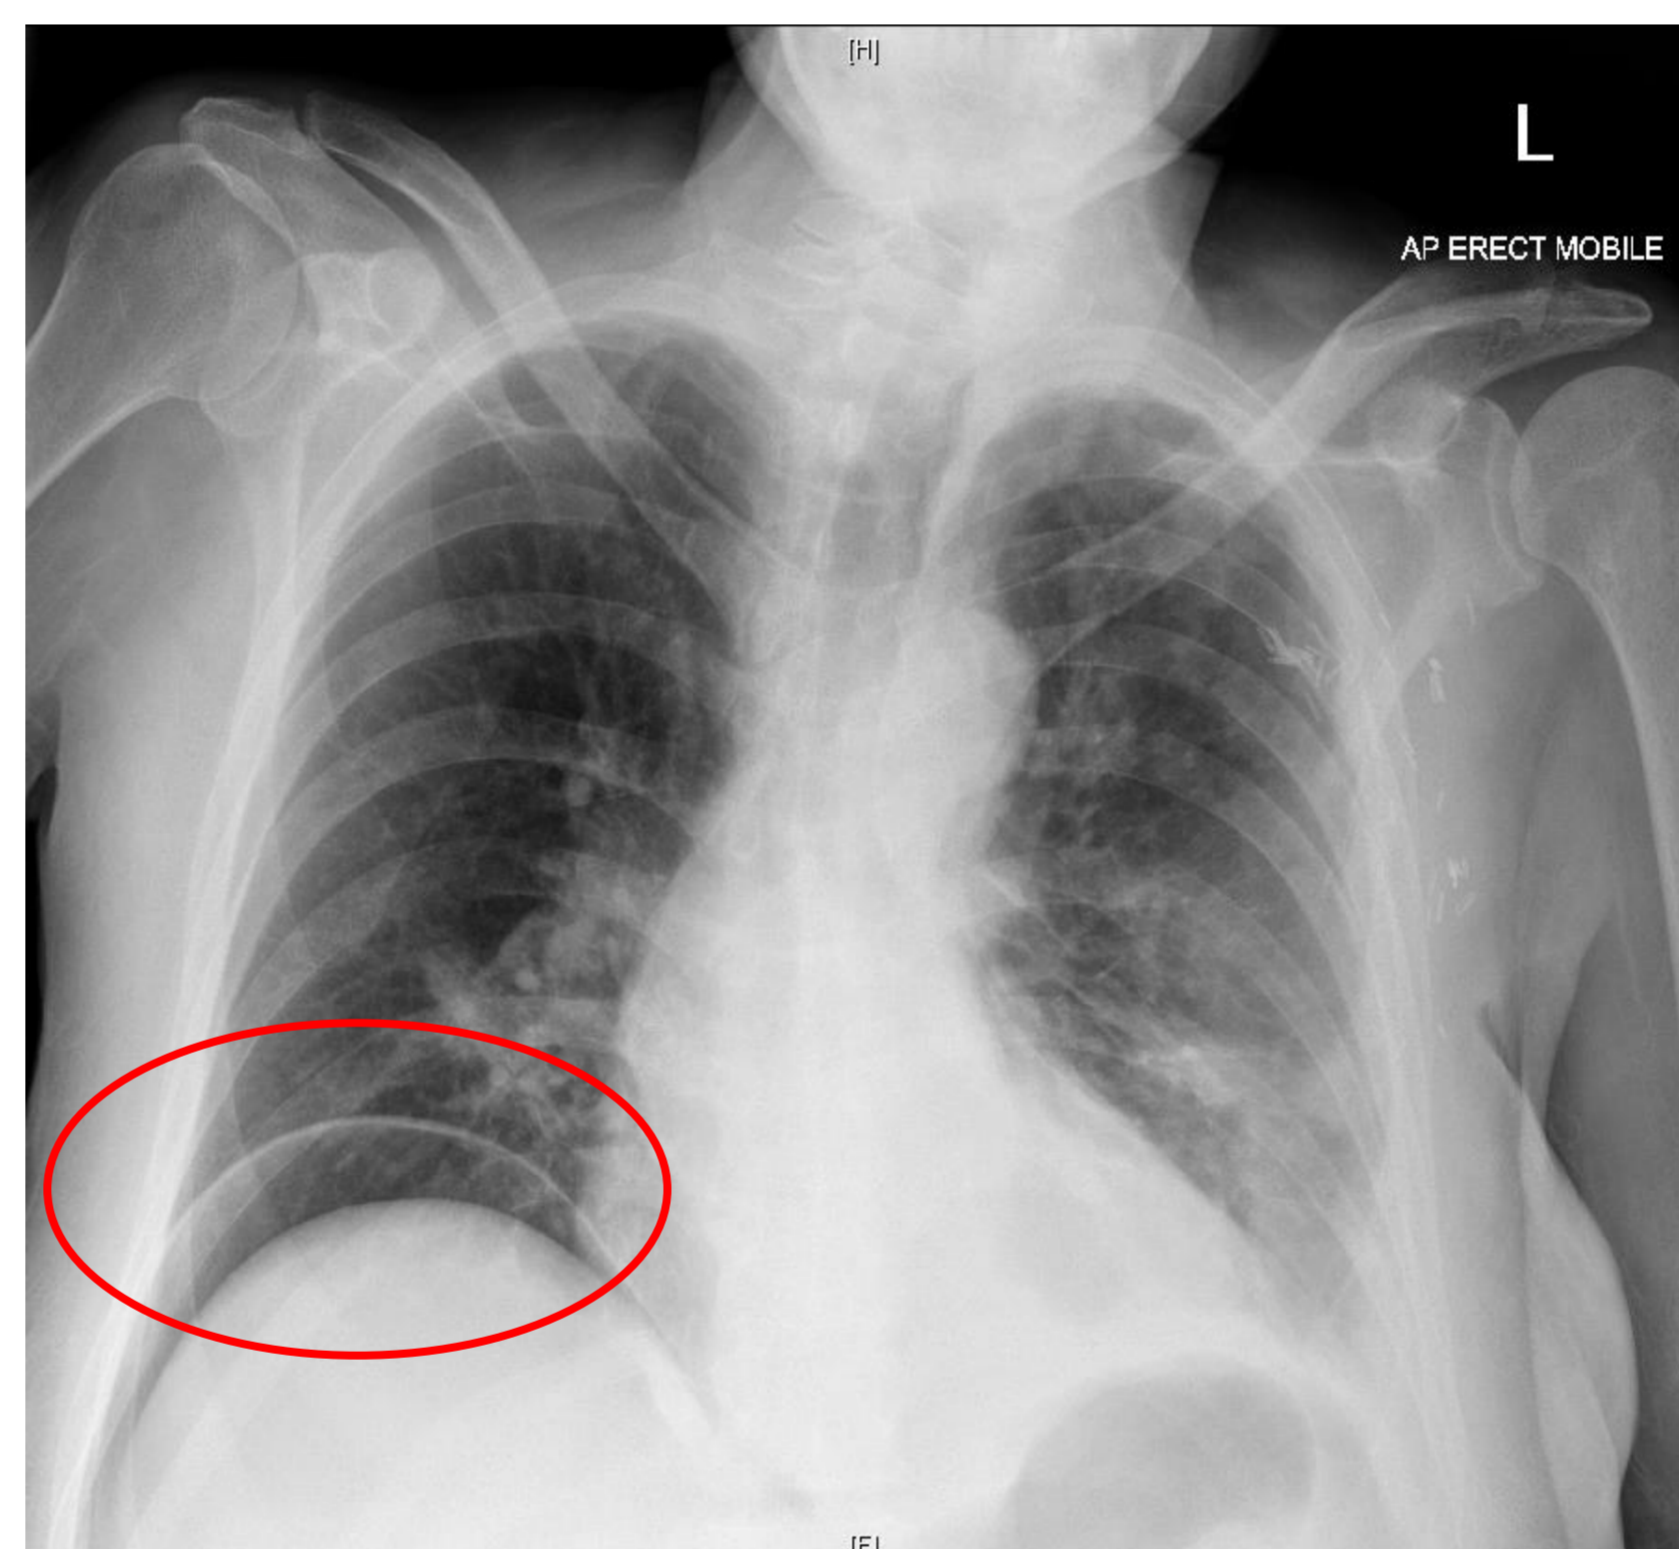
Chest X-ray of Case 2 showing gas beneath the right hemidiaphragm consistent with bowel perforation
